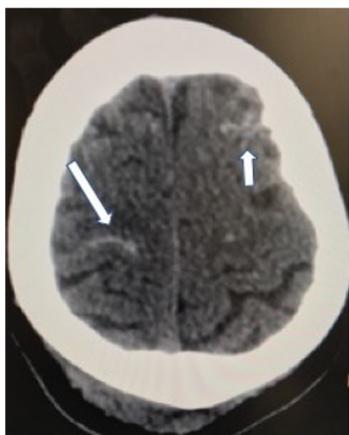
CT scan brain showing subarachnoid hemorrhage (marked by arrow).
